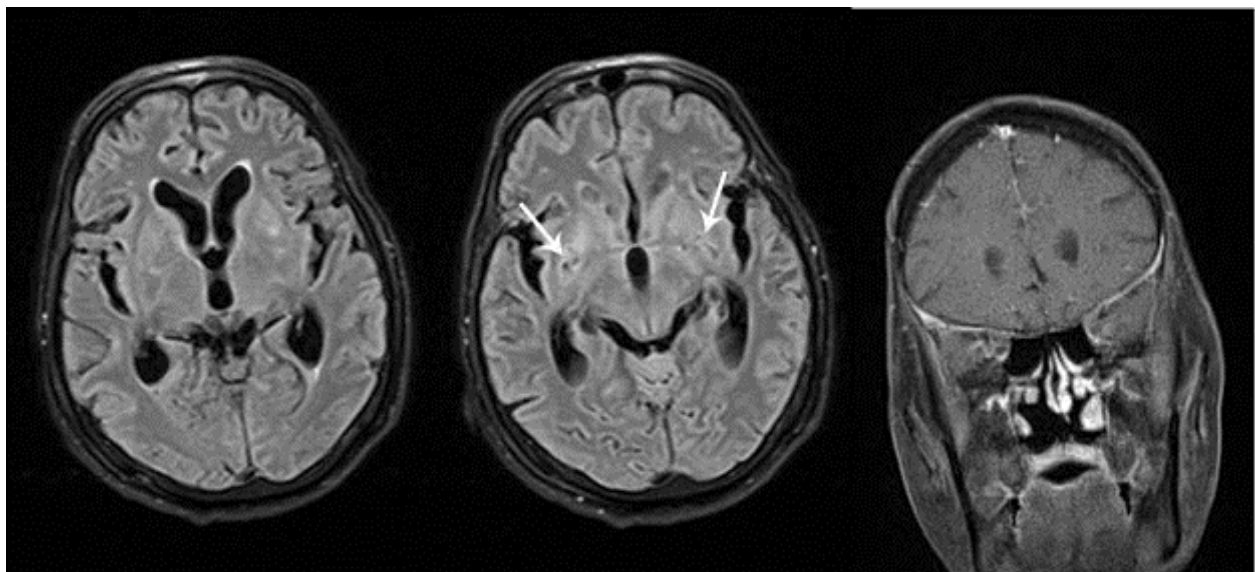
Brain magnetic resonance imaging (MRI) of the patient with cryptococcal infection shows bilateral enlarged perivascular spaces (white arrows) and basal ganglia hyperintensities in fluid-attenuated inversion recovery MRI along with bilateral mild basal leptomeningeal enhancement in contrast-enhanced MRI
